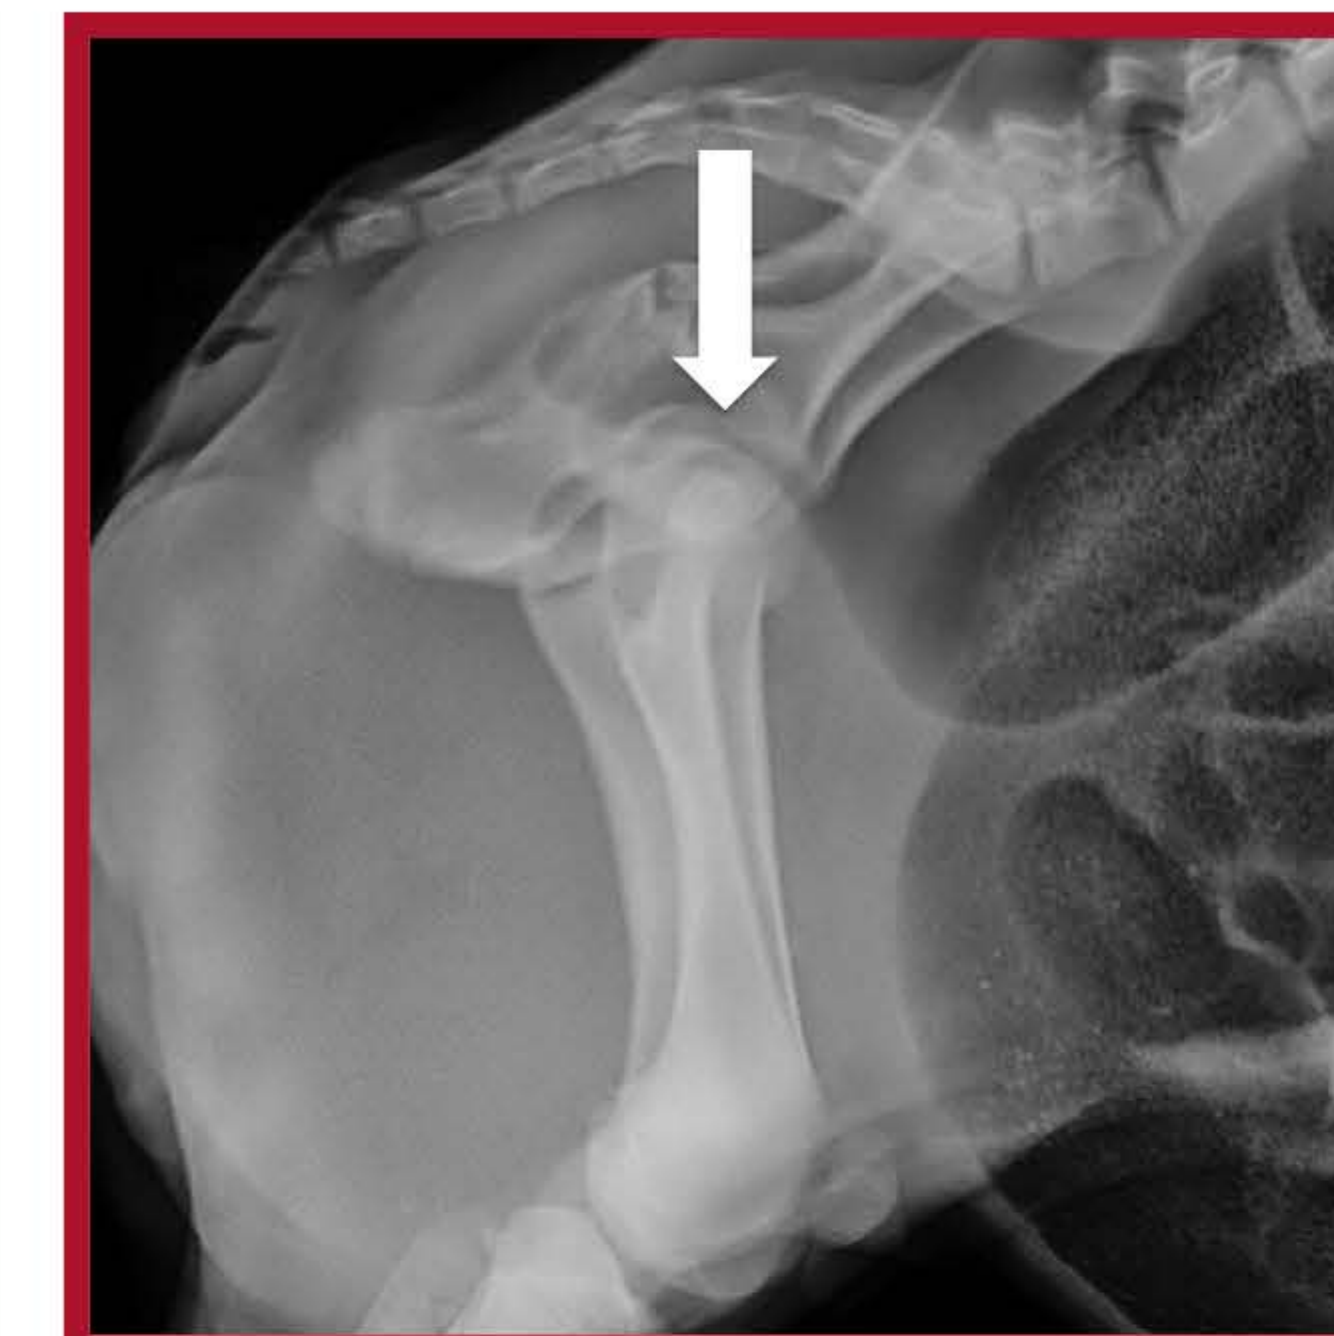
Lateral radiographic view showing no gas detected from mid-pelvis to the rectum (arrow).
